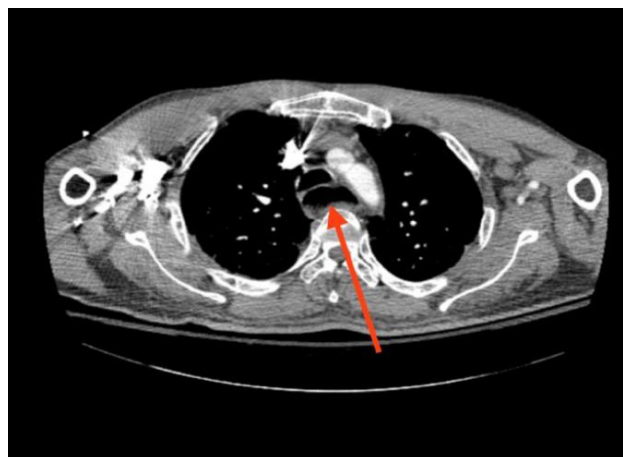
A computed tomography scan of the chest showing dilated oesophagus with fluid secretion (red arrow).
